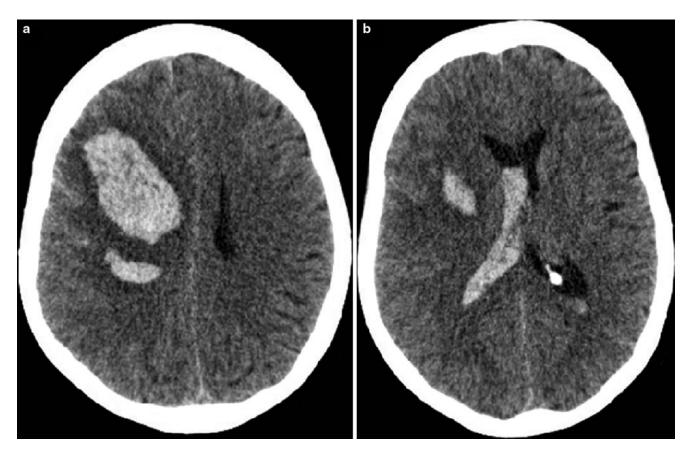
Preoperative CT-scan demonstrating a large right-frontal ICH and a smaller right central ICH with moderate displacement of midline structures (a) and deeper ICH components and unilateral ventricular hemorrhage (b)
